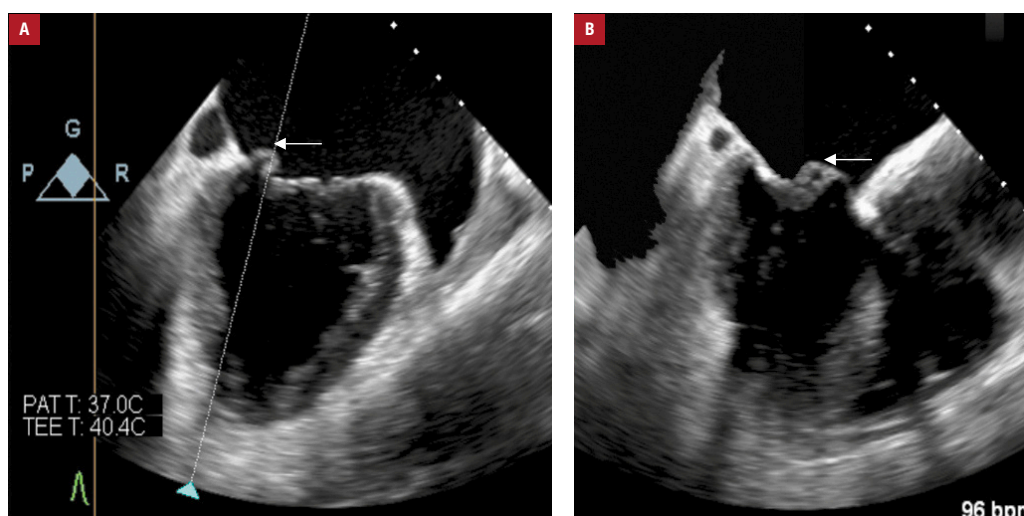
Transesophageal echocardiography: A – bicommissural view; the arrow indicates the site where the abnormality is seen; B – orthogonal view over the medial segment of the bicommissural view; the arrow shows the abnormality
